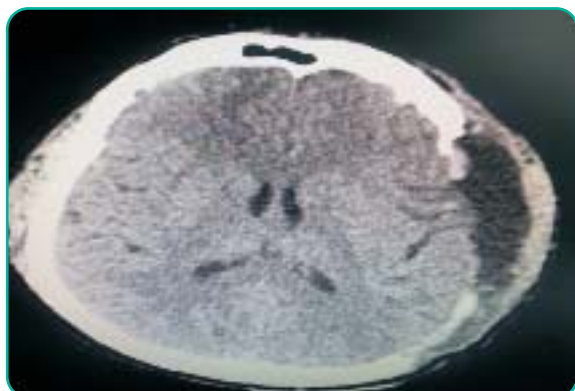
(postop CT brain)
